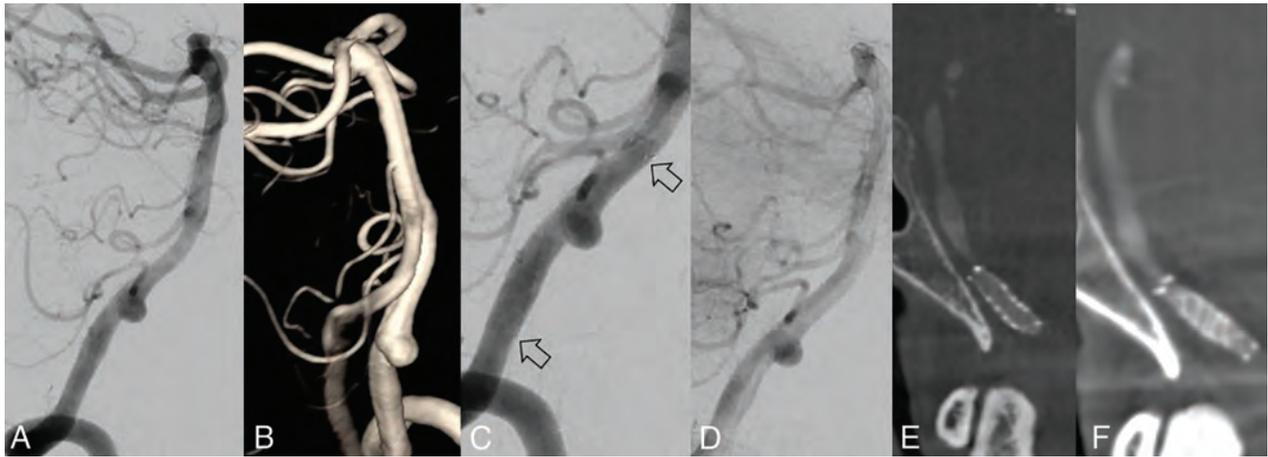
A 66-year-old woman presenting with an unruptured left vertebral artery aneurysm measuring 5 mm in maximum diameter. *A*, Lateral view of a left vertebral artery digital subtraction angiogram. *B*, Rotational 3D reconstruction. *C*, Angiogram post-FRED placement (arrows show the proximal and distal ends of the flow diverter). *D*, Stasis in the aneurysm after flow-diverter placement. *E*, Conebeam CT with contrast 1 month after stent placement shows complete occlusion of the aneurysm. *F*, Confirmation of aneurysm occlusion at 1 year.
